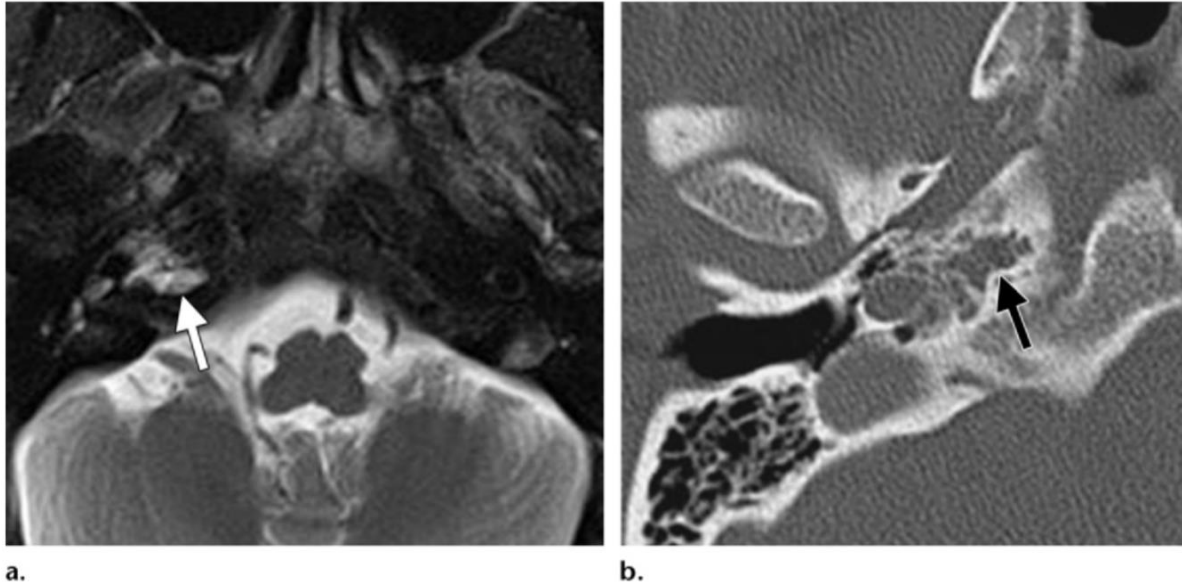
Petrous apex effusion. (a) Axial T2-weighted MR image shows asymmetric high signal intensity in the right anterior petrous apex (arrow). (b) Axial CT image shows that the abnormality represents opacified air cells in the anterior petrous apex (arrow). The lack of osseous destruction or bone remodeling helps distinguish trapped fluid from a tumor or mucocele.
